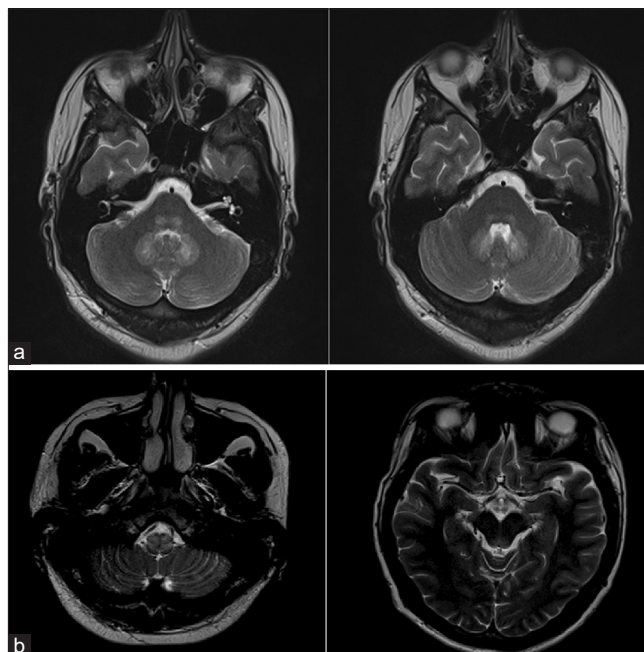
(a) MRI T2w images of brain showing symmetrical areas of hyperintensities in the bilateral cerebellar dentate nuclei and dorsal Pons. (b) MRI T2w images of brain showing symmetrical areas of hyperintensities in the bilateral Medulla and dorsal midbrain
